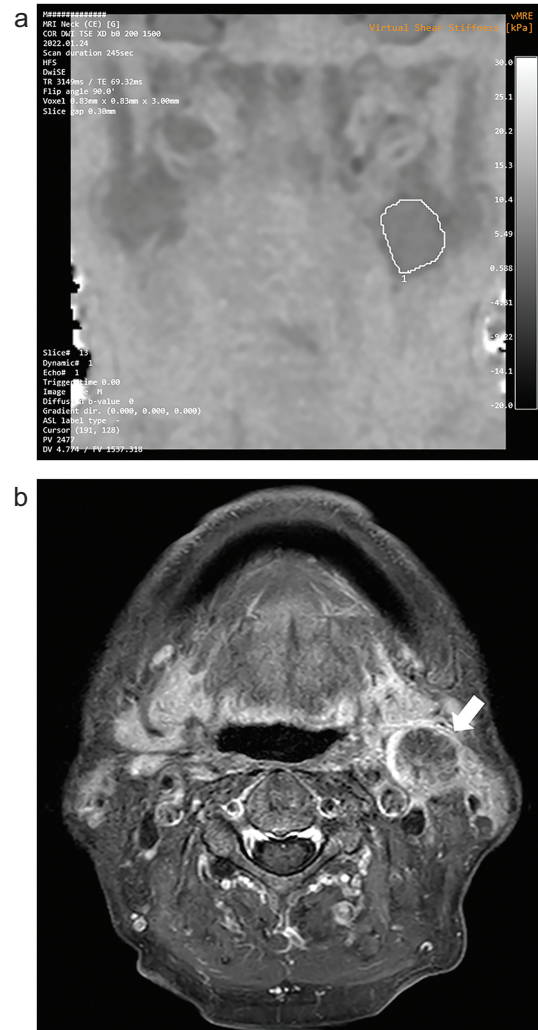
A 66-year-old male with left tonsillar squamous cell carcinoma with left level II lymph node metastasis. (a) DWI-based virtual MR elastography map is generated. (b) An ROI is placed on the metastatic lymph node to include the entire region of the node. (c) Contrast-enhanced coronal T1-weighted image shows the metastatic node (arrow). DWI, diffusion weighted imaging.
